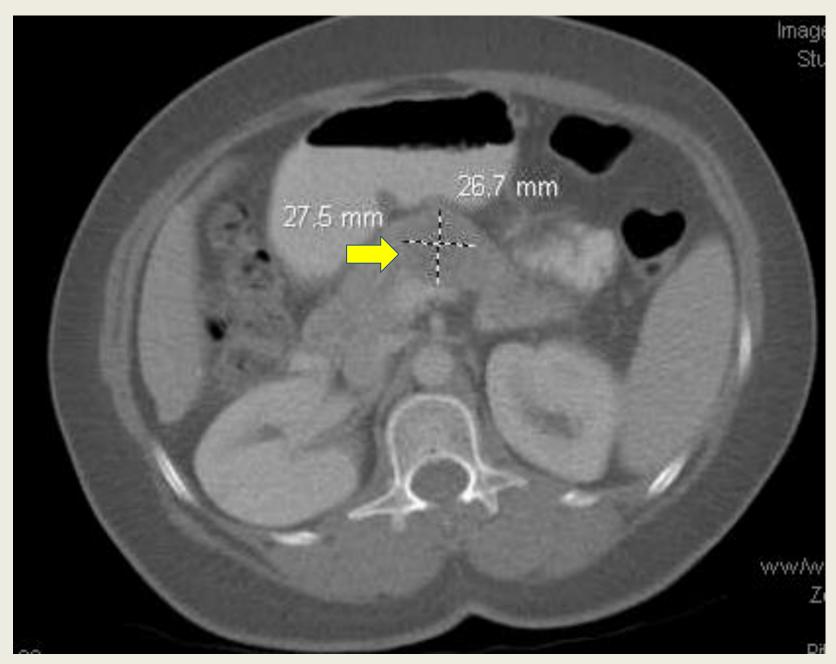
Surveillance CT demonstrating recurrence in the body of the pancreas
